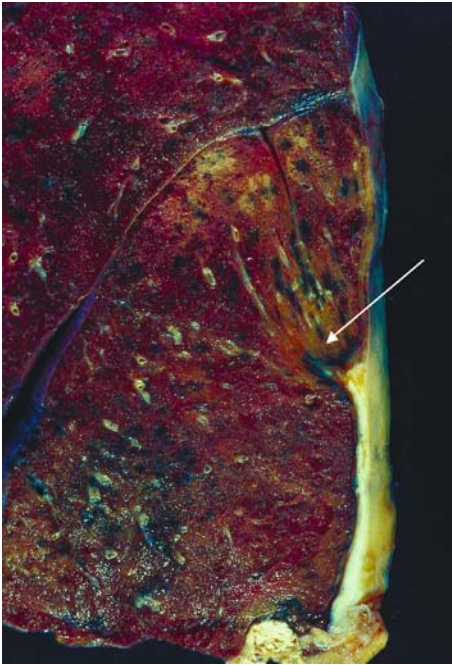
Rounded atelectasis. The lesion is caused by pleural scar forming under a plaque with traction and twisting of the underlying lung (arrow) to produce a radiographically visible lesion. From CHURG and GREEN (1998), used with permission
